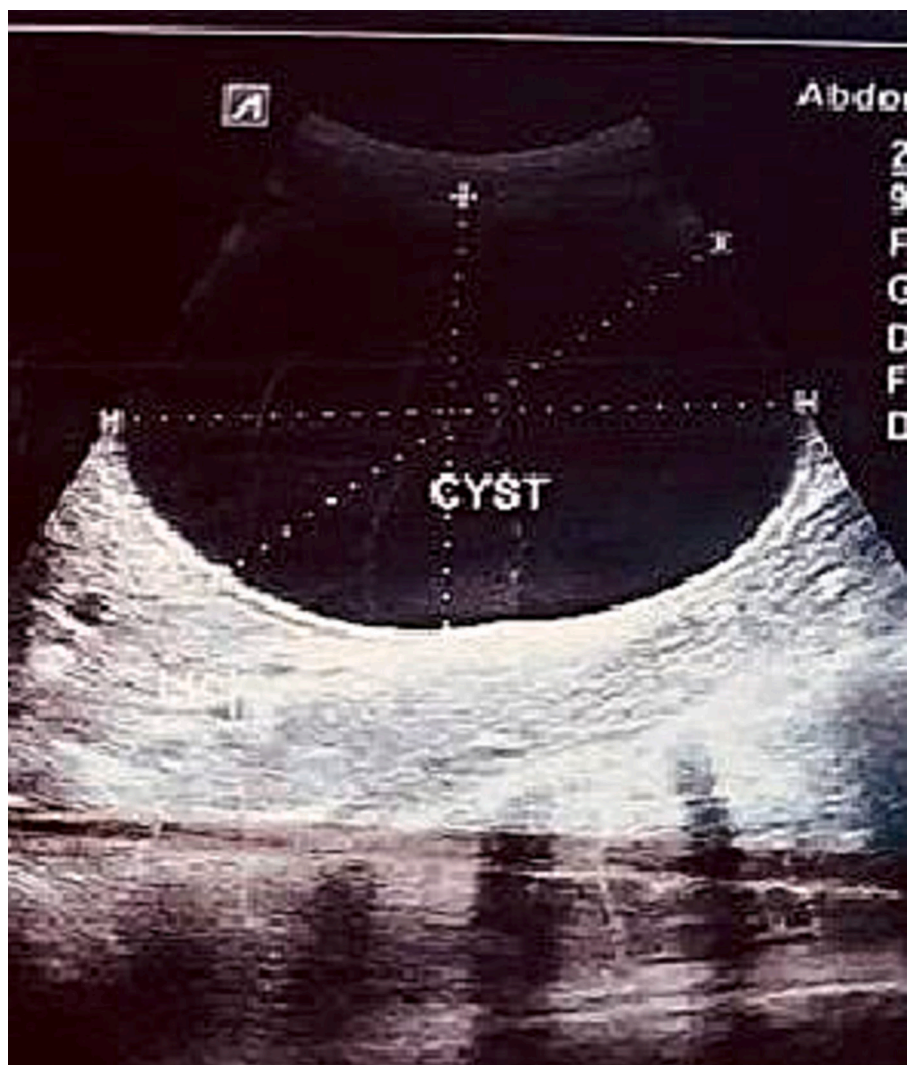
Ultrasound finding showing well-defined large anechoic lesion.
